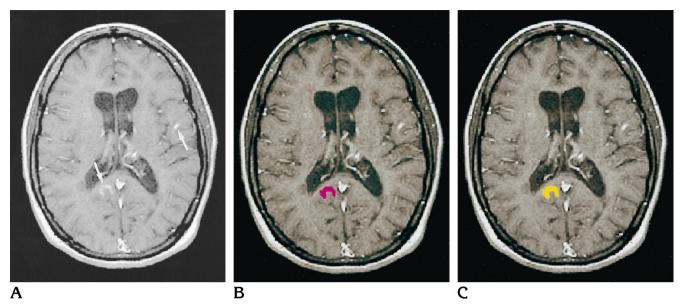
A, Contrast-enhanced T1-weighted MR image shows enhancing MS lesions (arrows).
